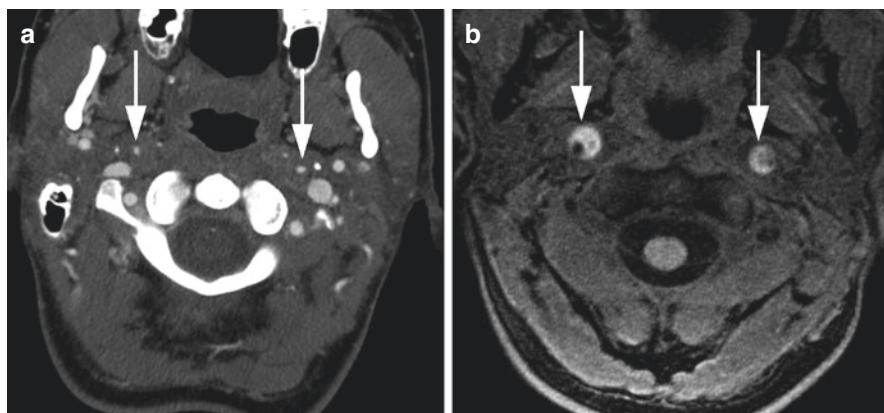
Cervical internal carotid artery dissection. Patient with bilateral cervical ICA dissections. CTA (a) showed bilateral severe cervical ICA lumen narrowing (arrows). MRI T1-weighted images (b) demonstrated large bilateral T1-hyperintense intramural hematomas (arrows)
